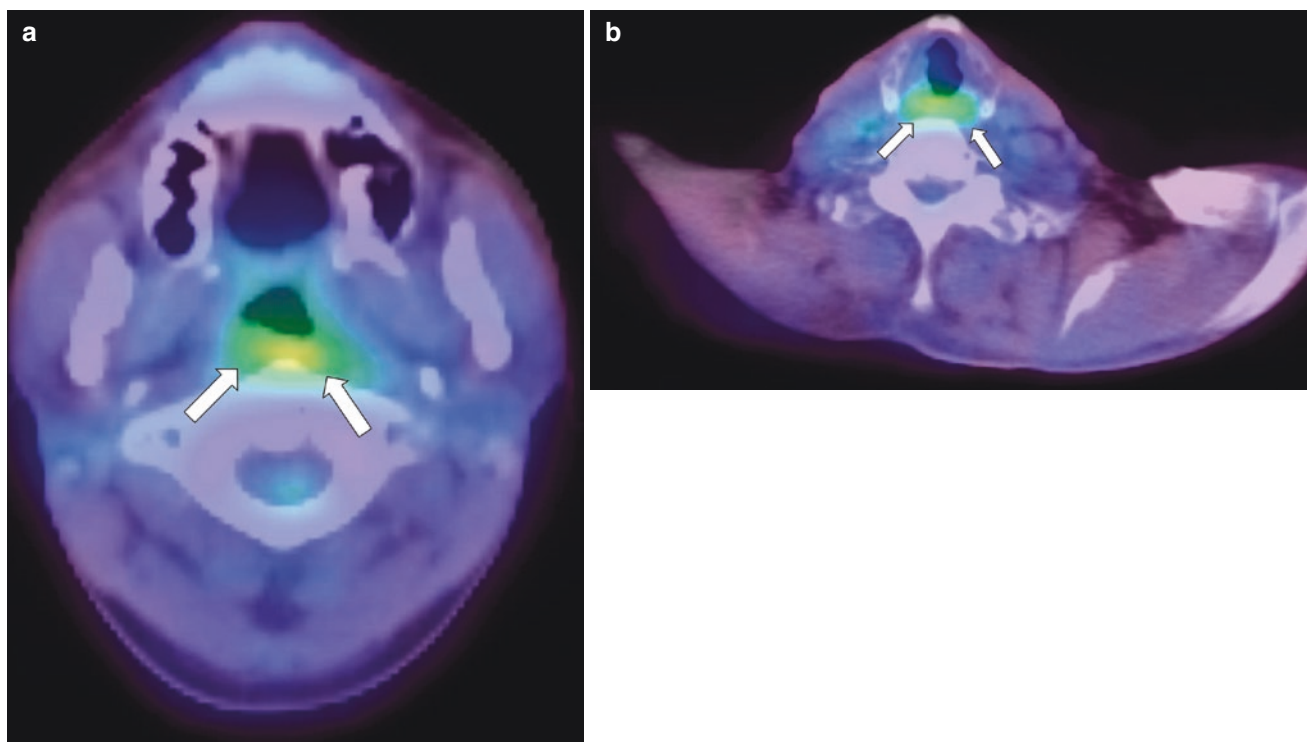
A 43-year-old man with nasopharyngeal carcinoma. The fused PET images scanned 3 months after the completion of radiation therapy presented moderate FDG uptake on the primary lesion (SUVmax 4.38) (a, *arrows*). Direct inspection by endoscopy identified the uptake as posttreatment changes. Another 72-year-old man with hypopharyngeal carcinoma displayed inflammatory FDG uptake
